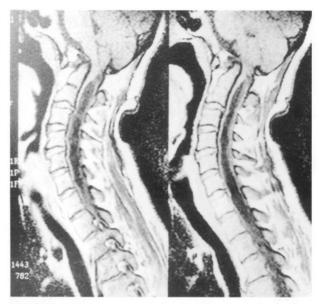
Large syringomyelia cavity extended to bulbus is observed in preoperative MRI of a patient with a Chiari type I malformation. Compression of the subarachnoid space anterior to the brainstem is also observed.
